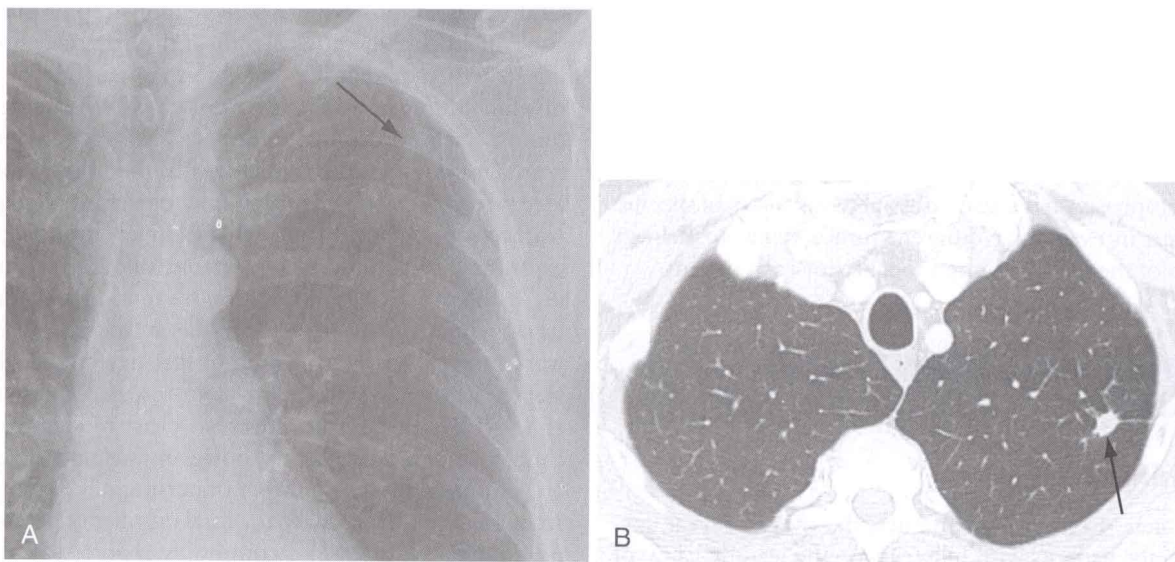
A, Incidental nodule in a 67-year-old man was discovered on a routine chest radiograph. The small nodule is barely visualized because it is superimposed on ribs (arrow). B, Contrast-enhanced chest CT scan shows a spiculated 1.3-cm nodule (arrow). Transthoracic needle biopsy revealed respiratory epithelial cells and histiocytes in a background of extensive necrosis but no malignancy. The nodule nearly completely disappeared without therapy over a period of 3 years, confirming the benign diagnosis.
